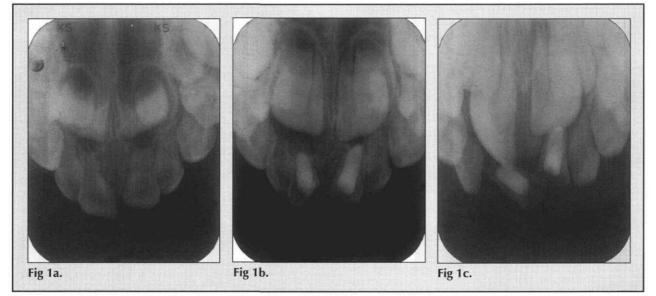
Preoperative facial radiograph of two central incisors with necrotic pulps. Note the normal position of the two permanent central incisors. Patient was age 33 months and had traumatized the teeth 1 year before. Both incisors were judged to have excess (> 1 mm) preoperative root resorption. Fig 1b. An 18-month postoperative radiograph of the same patient's incisor PEs. The maxillary left PE incisor was judged a success and filled to the apex. The maxillary right incisor was judged a short fill and was a failure. Fig 1c. The same patient's radiograph at age 7 1/2 years. Note that the permanent right central incisor was erupting ectopically to the palatal aspect of the overretained but very loose primary right central incisor. Both PE teeth were extracted. The central incisors erupted into normal positions after minor orthodontic treatment.
